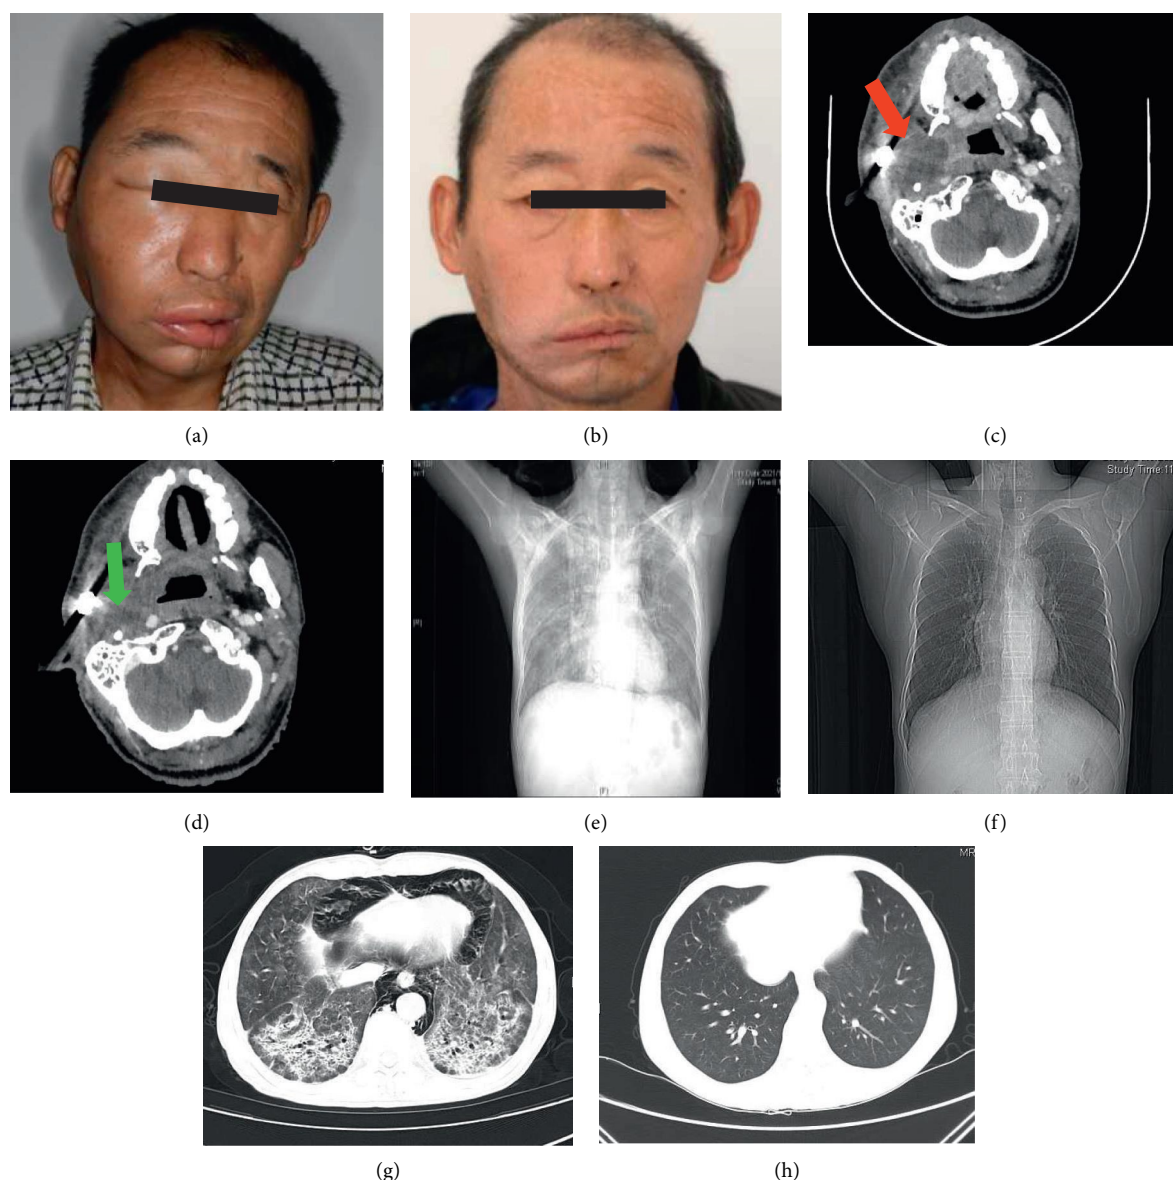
Patient No. 7 experienced tumor recurrence on the right maxilla and an invasion into the pterygoid plate ((a); (c) red arrow). Partial response occurred after four cycles of pembrolizumab treatment ((b); (d) green arrow). Interstitial pneumonia in both lungs was observed after seven cycles of pembrolizumab treatment ((e) chest radiograph; (g) chest computed tomography). The serial images indicate that the immune-related adverse events were controlled following seven days of methylprednisolone treatment ((f) chest radiograph; (h) chest computed tomography).
